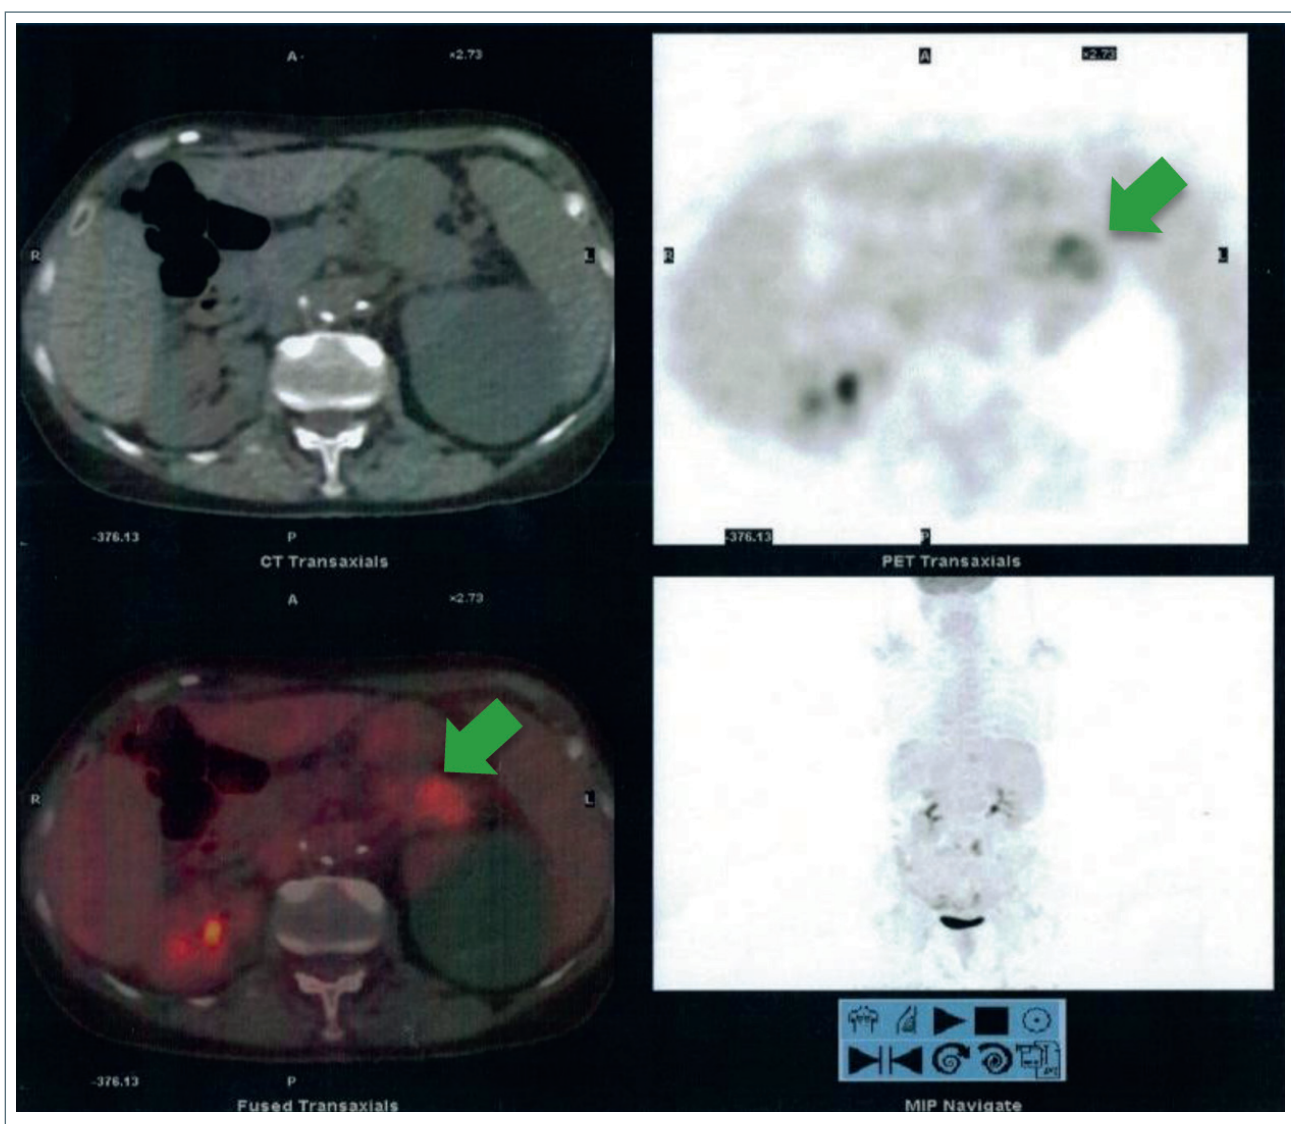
18F-FDG PET (November 2015): the pancreatic lesion show hypermetabolic activity (green arrow).
